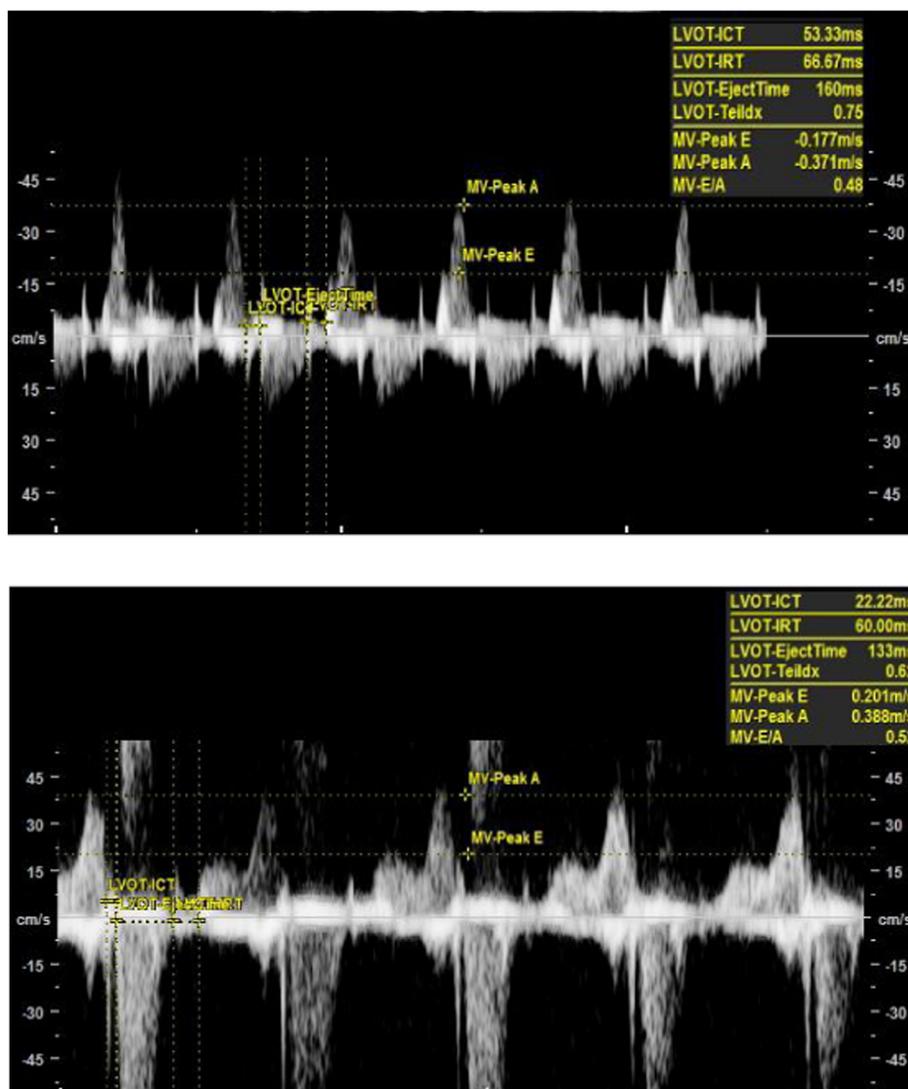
Abnormal myocardial performance index and E wave/A wave peak velocity ratio Doppler tracings at the mitral valve
